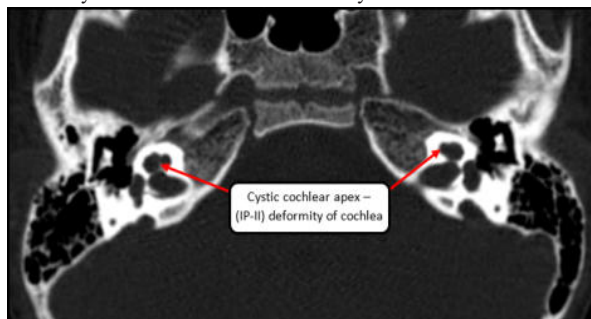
HRCT scan of temporal bones of child showing bilateral IP-II deformity of cochlea
